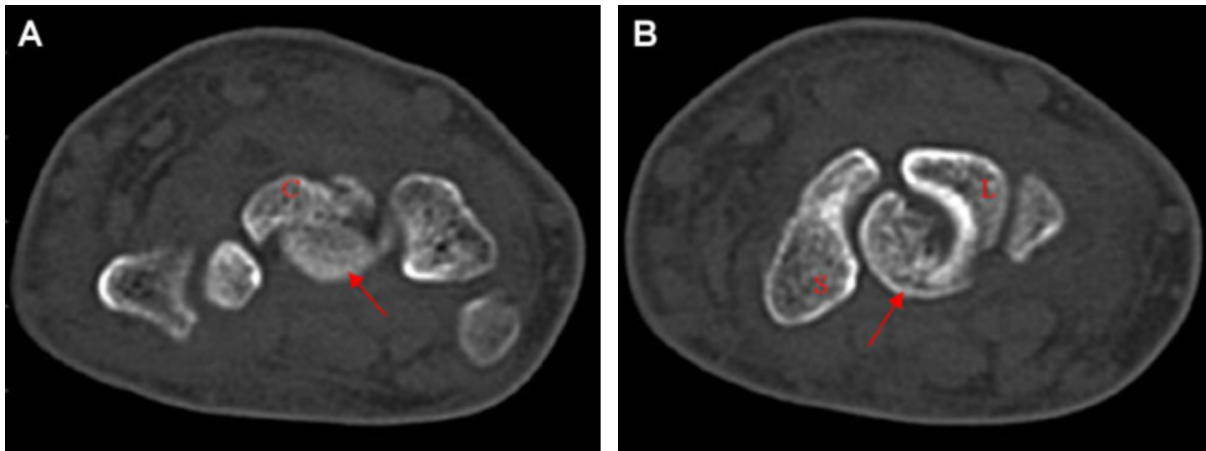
Axial CT images demonstrate the proximal capitate fracture (arrows). S = scaphoid. L = Lunate. C = distal capitate fragment.
